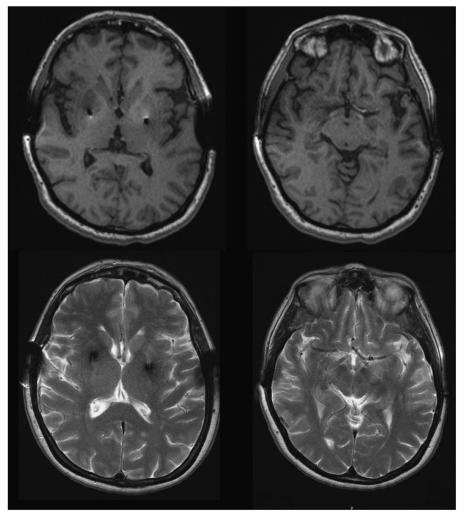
Brain MRI, T1 and T2-weighted images at the age of 65 showed no abnormal findings aside from bilateral GPi electrodes.
